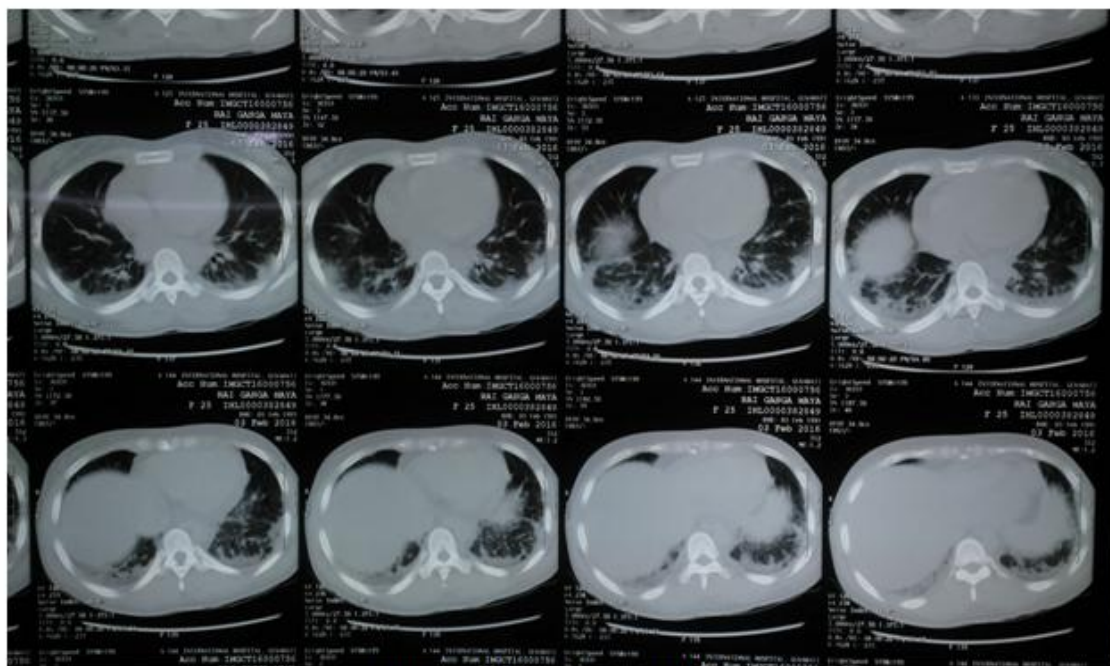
CT thorax showing ILD
